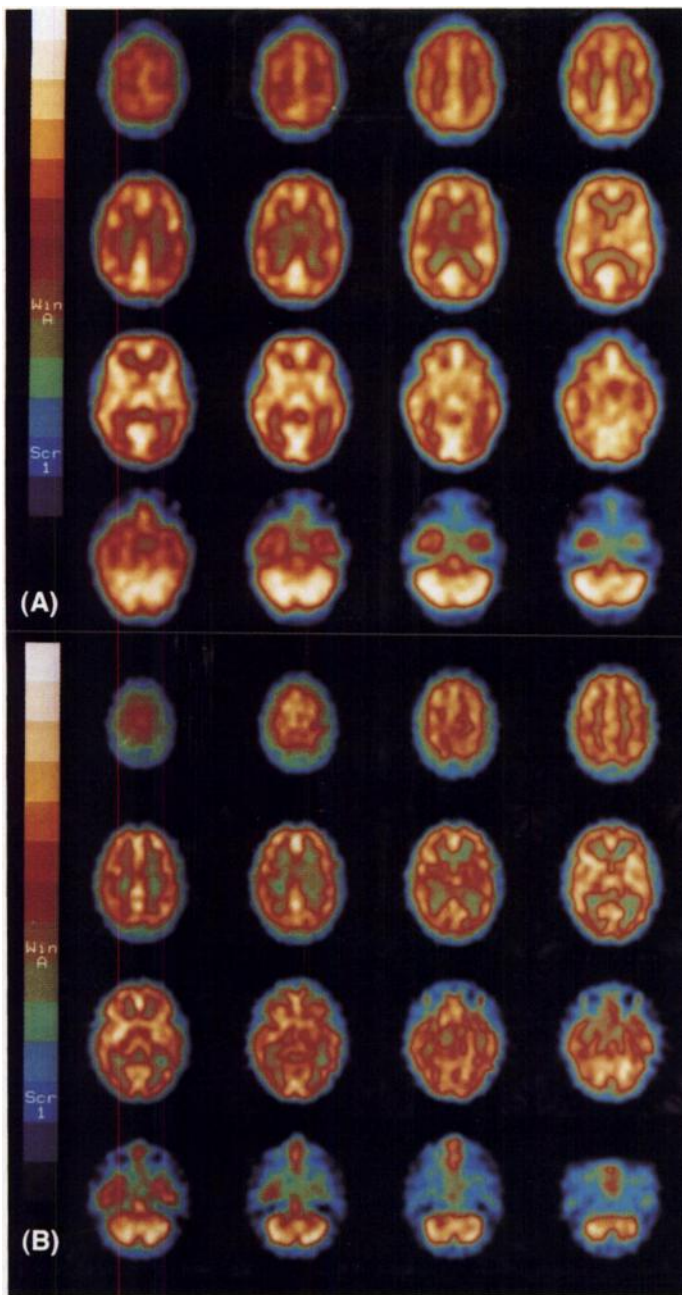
Transaxial slices (SPECT) in two patients with aseptic meningoenkephalitis. (A) Woman (19 yr) with HSV 2 meningitis and cognitive dysfunction (decreased concentration) examined 39 days after onset. Normal rCBF. (B) Male (17 yr) with enteroviral disease (echo 30), with no remaining neurological or cognitive symptoms, examined 35 days after onset. Decreased rCBF with generally patchy pattern bilateral (flow rate 1).
